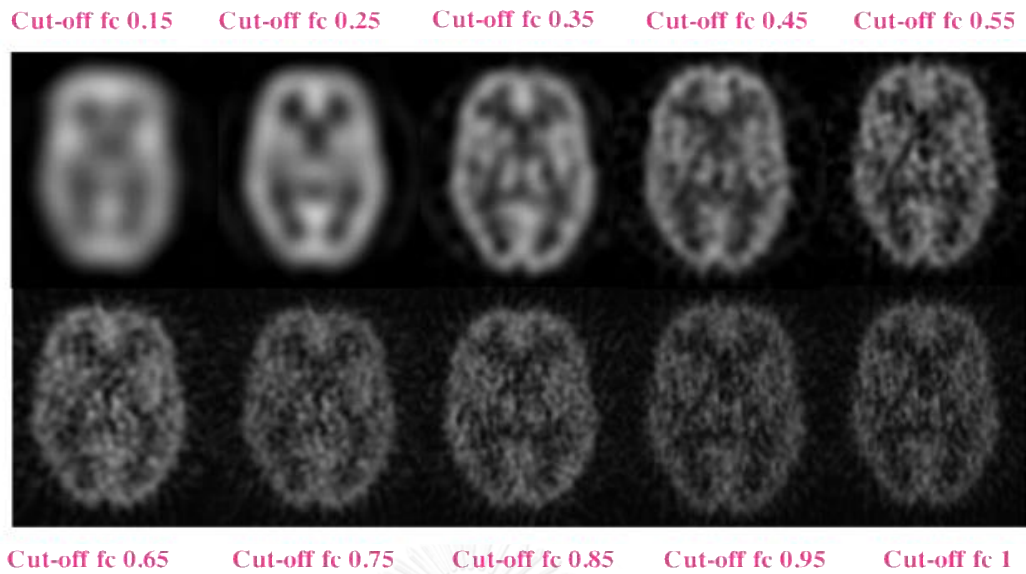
Figure B 4 The brain SPECT images by varying cut-off frequencies in normal activity concentration (FBP method)
